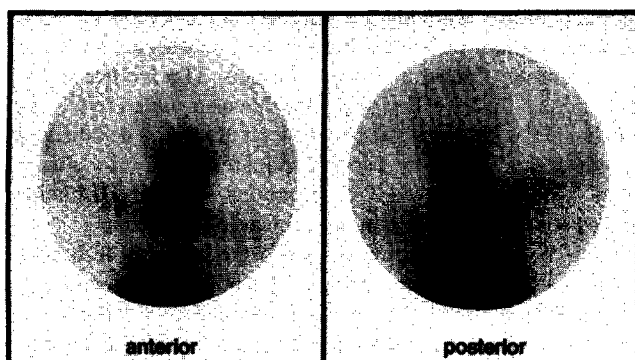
[^{111}In]Antimyosin scintigram of a 3-year-old boy with a primary RMS in the right thorax aperture (grade 2 uptake).
